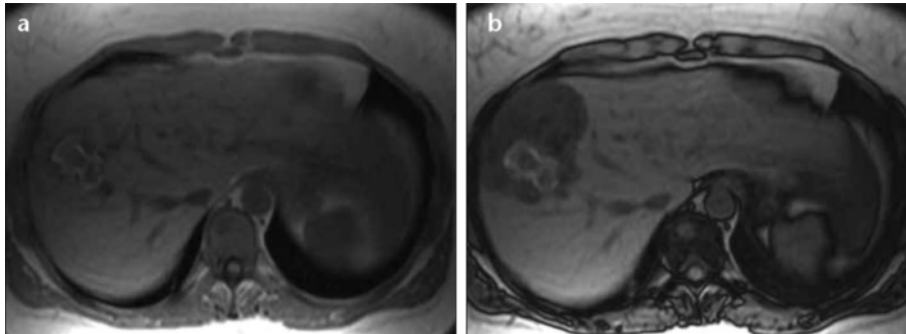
Axial T2-weighted (a), venous phase T1-weighted and 20 minutes T1-weighted MR images of a patient with typical 'spoke wheel' aspect typical for a FNH. A central scar with divergences to the periphery is visible on T2-weighting, reminiscent of a spoke wheel (a). These so-called 'spokes' are enhancing in the venous phase normally using an aspecific contrast agent or gadobenate dimeglumine. But when using gadoxetate disodium, the central scar and the spokes stay hypointense due to pseudo wash-out (b). After 20 minutes the majority of the lesion (except the scar) becomes hyperintense owing internal bile duct proliferation (c). FNH = focal nodular hyperplasia.
